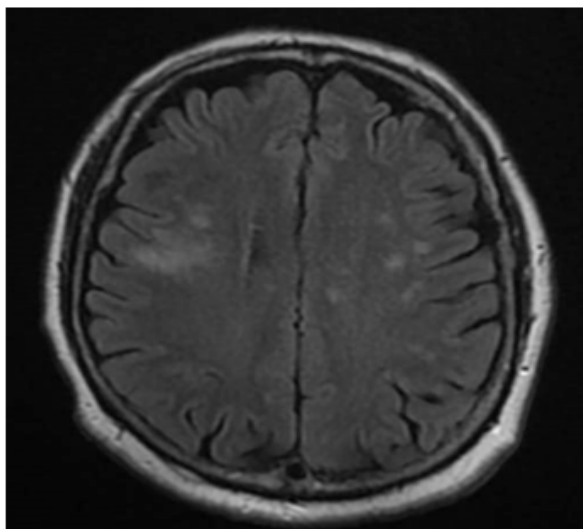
Axial MRI FLAIR sequence showing adjacent gliotic changes in hyperintense signal.
